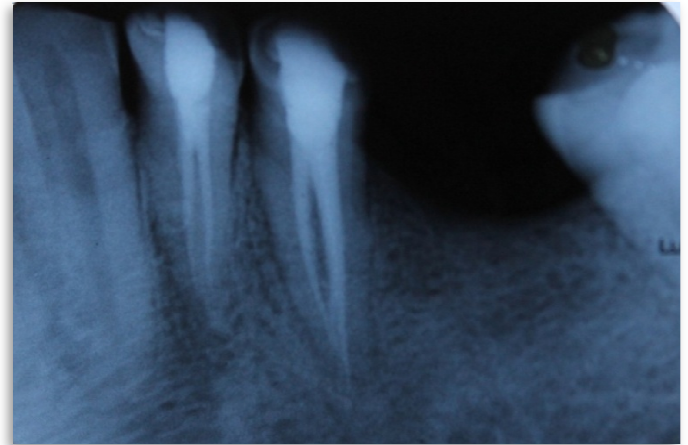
Periapical radiograph after obturation
